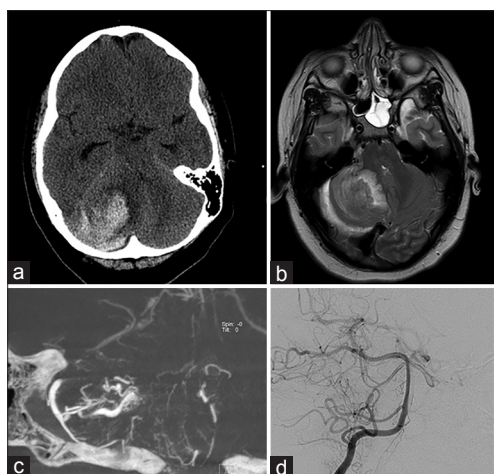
Right cerebellar hemorrhagic lesion from Case 2. (a) Computed tomography of the head at presentation showed a large hemorrhage of the right cerebellar hemisphere with displacement of the fourth ventricle. (b) Magnetic resonance imaging brain, T2 sequence showed perilesional edema and some associated vessels. (c) Right vertebral artery injection DynaCT, coronal view, showed an arteriovenous malformation with feeders from the right anterior and posterior cerebellar arteries. (d) Postoperative angiogram, AP projection, showed no residual malformation
